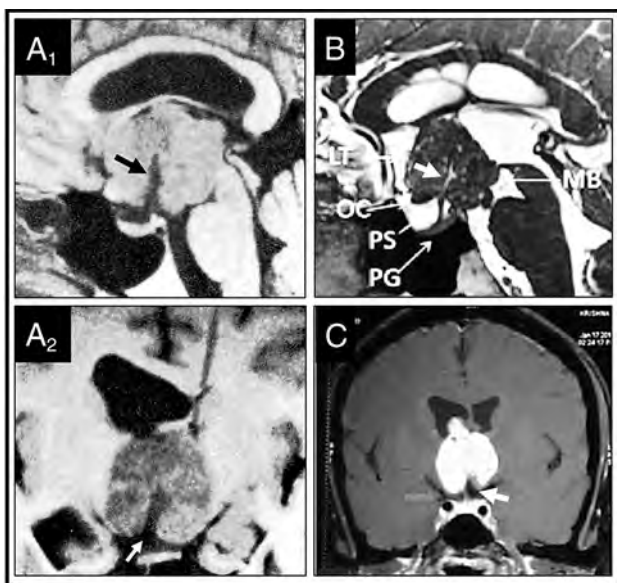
Basal recess at the infundibular portion of 3V papillary craniopharyngiomas. MR imaging characterization in seminal cases from the medical literature (A₁–A₂). Diverticulum-like recess at the base of a strict 3V papillary CP identified on preoperative MR imaging (Online Supplemental Data). On the midsagittal T1WI (A₁), the hypointense recess (black arrowhead) is open at the suprasellar cistern and extends to the tumor center, following the same trajectory as the PS. The coronal-transinfundibular MR image (A₂) shows the hypointense signal of the recess identical to CSF, indicating free passageway of CSF between the suprasellar cistern and the recess and the rounded dead end of the recess at the tumor center. Reproduced with permission from the Fukushima et al.⁸ B, Duct-like long-recess type in a strict papillary CP (Online Supplemental Data). This midsagittal T2WI shows the hyperintense signal of the duct, identical to that in the CSF (white arrow). Reproduced with permission Gu et al.²¹ C, Coronal-transinfundibular T1WI of a short-type basal DR in a strict 3V PCP (Online Supplemental Data). Note the isointense rim of the 3V floor covering the undersurface of this solid homogeneously gadolinium-enhancing tumor and how the 3VF invaginates at the midline of the basal pole of the CP to form the recess (white arrow). Reproduced with permission from Rambarki and Rajesh.²² PG indicates pituitary gland; MB, mammillary body; OC, optic chiasm.
